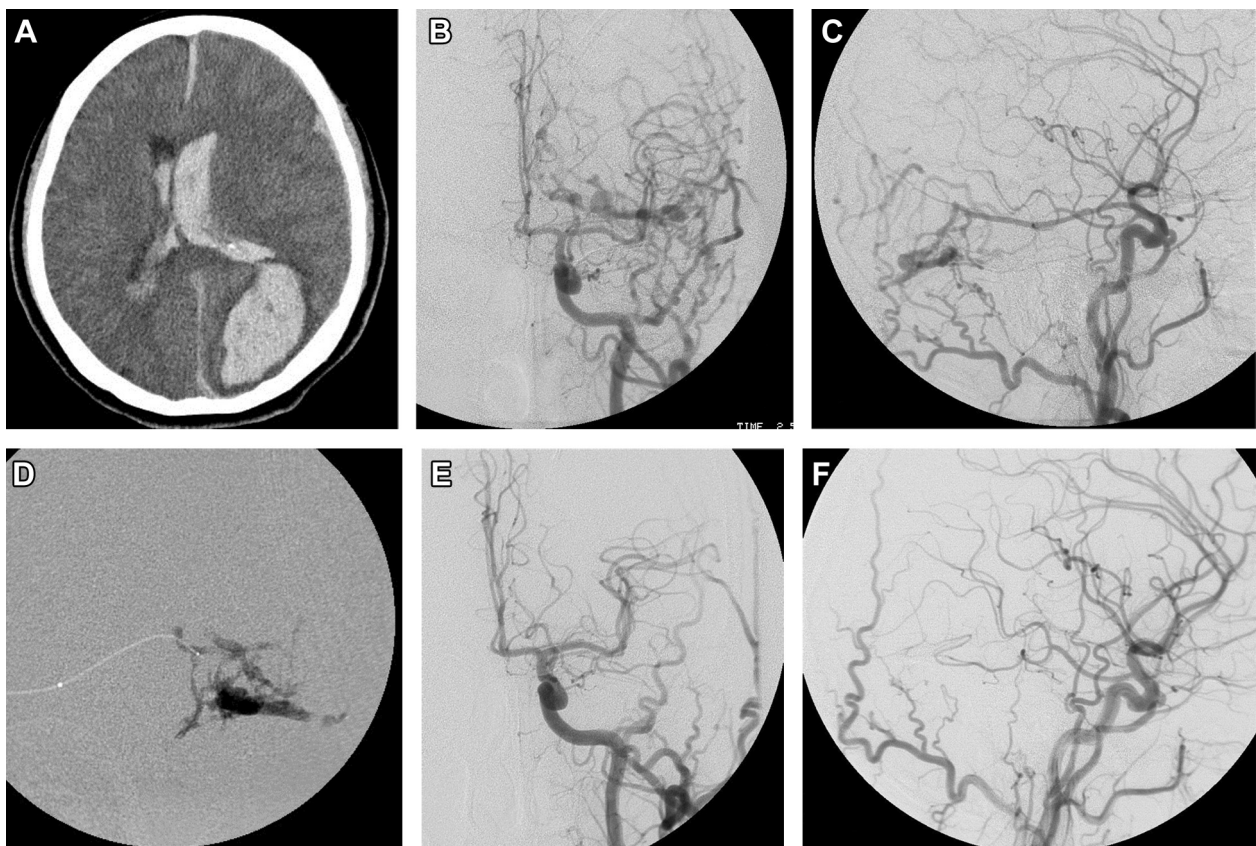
A 61-year-old woman presented with consciousness change. (A) Brain computed tomography demonstrated intracerebral hemorrhage with extension to ventricular systems; subdural hematoma was found as well; (B, C) left carotid angiograms depicted Cognard type IV dural arteriovenous fistulas at the left posterior tentorium; (D) the patient underwent transarterial (middle meningeal artery) n-butyl-2-cyanoacrylate embolization; and (E) postembolization angiograms demonstrated total fistula occlusion.
